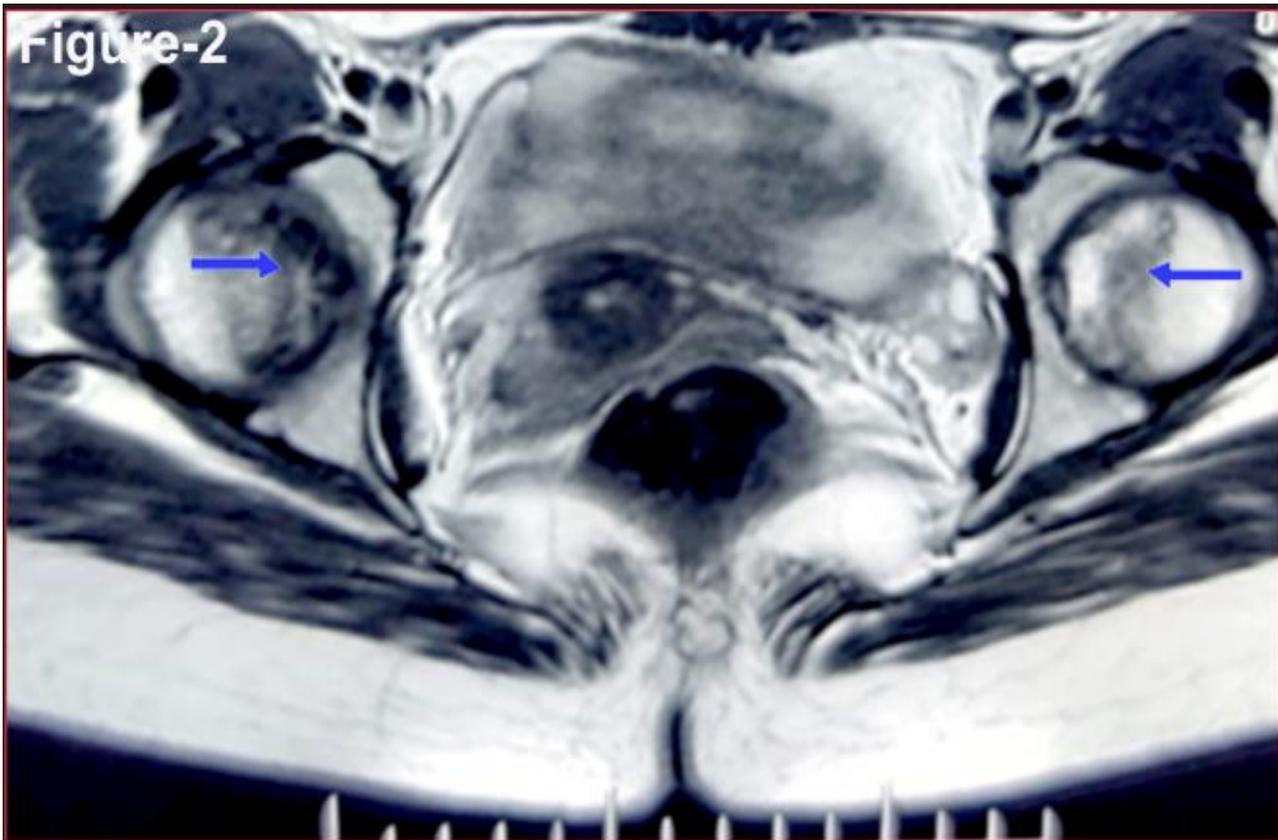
MRI hip joint showing bilateral asymmetric T2 hypointensities (blue arrow) of medial portion of head of femur suggesting avascular necrosis of head of femur
